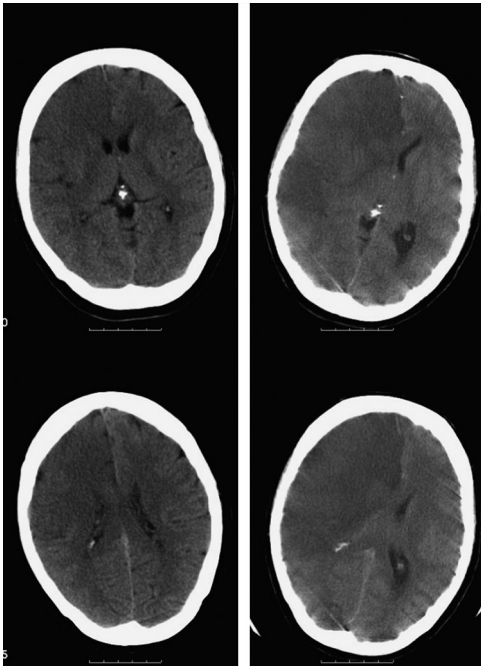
CT scans showing massive right hemisphere swelling. The two images on the left are from a scan at 4 hours post stroke and show early ischaemic changes in the right carotid (both MCA and ACA) territory. The corresponding images on the right are from a scan the following day and show an established infarct with brain swelling into the left hemisphere. © Hugh Markus.
